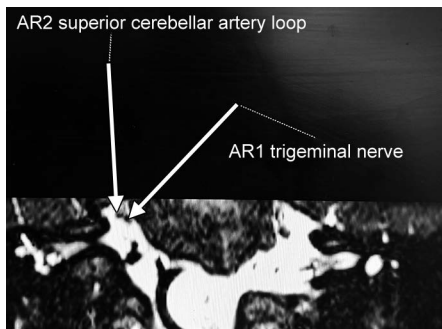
MRI showing neurovascular conflict between the right anterior inferior cerebellar artery and cisternal segment of the right trigeminal nerve
